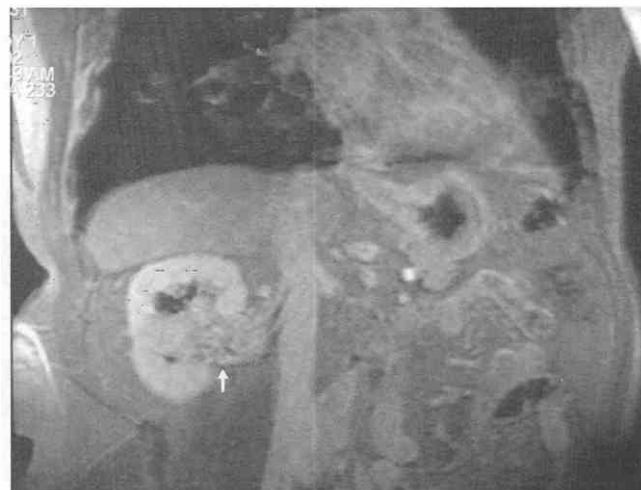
MR image obtained after gadolinium enhancement, in the same patient shown in Figure 41-62, demonstrates enlarged renal vein with enhancement (arrow). At surgery, the enlargement was confirmed to be tumor extension into the renal vein.
